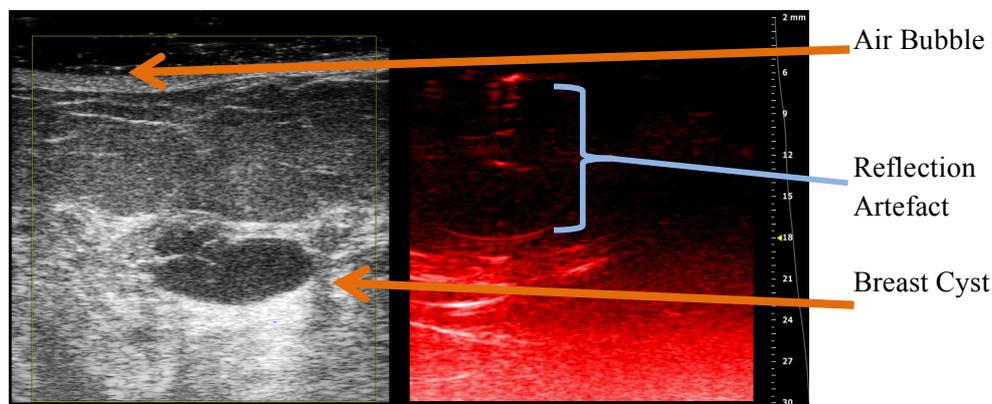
Image of a breast cyst. Reflection artefact is visible within the PA image (blue arrow) caused by the presence of an air bubble within the ultrasound gel on the probe.
